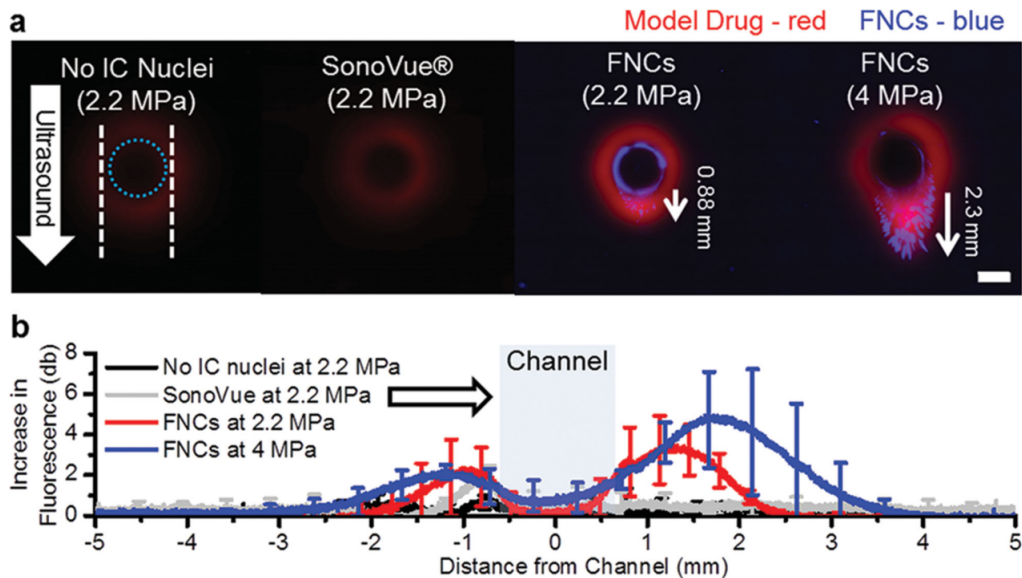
Nanocup penetration in a tissue model. a) Representative fluorescent images of the tissue model sliced radially to the channel after exposure to ultrasound for 5 minutes at 2.2 and 4.4 MPa. The white dotted lines indicate the edges of the ultrasound focus, and the dotted blue line represents the edge of the flow vessel. A white arrow demarcates the direction of ultrasound. In the images, the model drug (TRITCD) is labelled in red and the nanocups are labelled in blue (FNCs). The scale bar represents 1 mm, and is valid for all images. b) Average increase in fluorescence intensity profile plots of no cavitation nuclei, SonoVue, and nanocups at both 2.2 MPa and 4 MPa taken down the centre line and in the direction of ultrasound are shown for each test condition. The white arrow indicates the direction of ultrasound and the blue box represents the flow channel. TRITCD without cavitation nuclei and without ultrasound exposure was used as the reference value. For clarity, only 20 to 25 points are shown with standard deviations (Kwan et al. 2015b). (used with permission)
